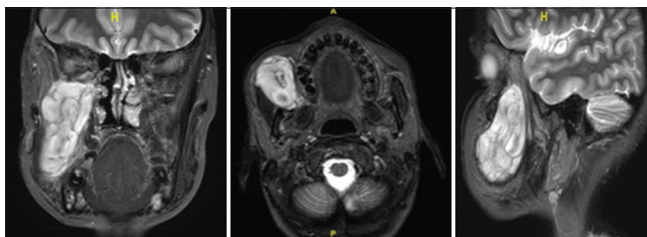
MRI of patient 1, showing well-defined soft-tissue density lesion in the right buccal space, extending into ipsilateral infratemporal fossa, pterygomaxillary fissure and pterygopalatine fossa with widening of the right vidian canal and foramen rotundum
